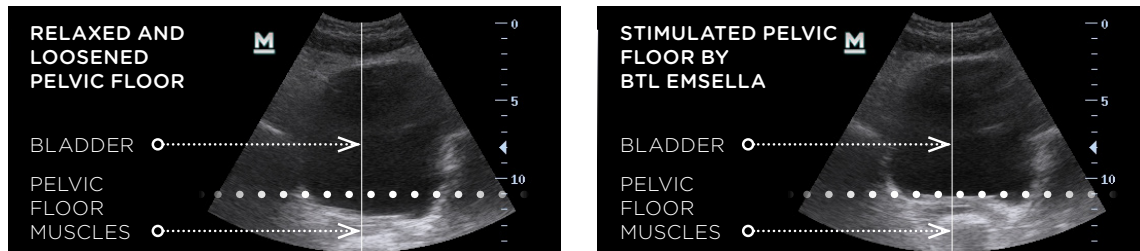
A frontal view of the pelvic floor muscles and bladder using medical ultrasound. Relaxed and loosened pelvic floor muscles and bladder (left). Stimulated and lifted pelvic floor muscles and bladder using HIFEM technology (right).
